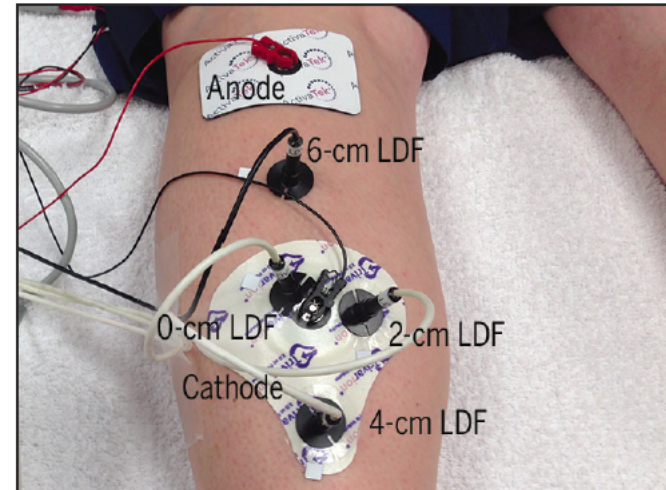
Placement of LDF probes to measure skin perfusion during iontophoresis treatment. The LDF probes were placed inside the drug chamber (0 cm), just outside the drug chamber (2 cm), and 4 and 6 cm from the center of the drug electrode. Abbreviation: LDF, laser Doppler flowmetry.
